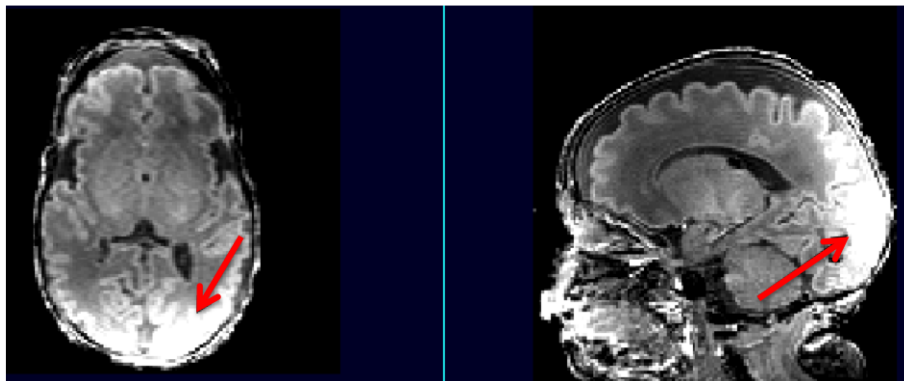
An example of severely bias-corrupted premature neonatal brain T1w brain MRI acquired on a Siemens Verio system using a 15 channel knee coil from PENUT [115] study [150]. Red arrow: hyper-intense WM that may be mis-labeled as GM without bias correction
